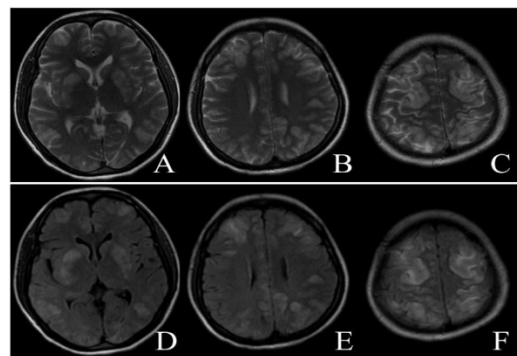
The MR images of the patient before treatment. It showed extensive hyper intense lesions in the basal ganglia and cerebral cortex of parieto-occipital lobes in T2-weighted images, including Flair images.
